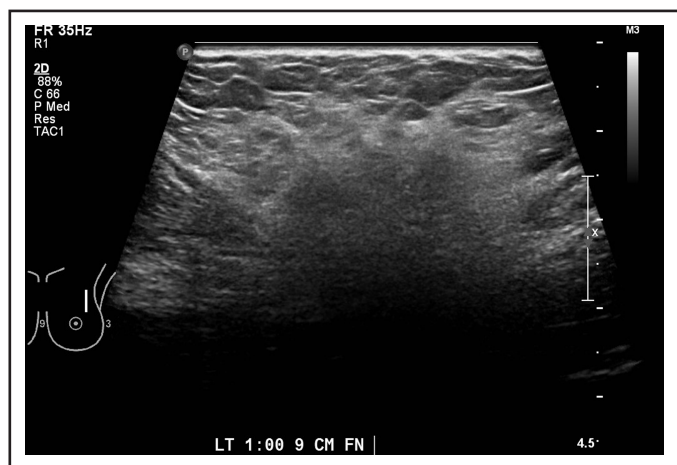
Ultrasound. L Breast- Ill-defined area located at 1 OC, 9 (CFN), measuring 2.2 x 2.1 cm
